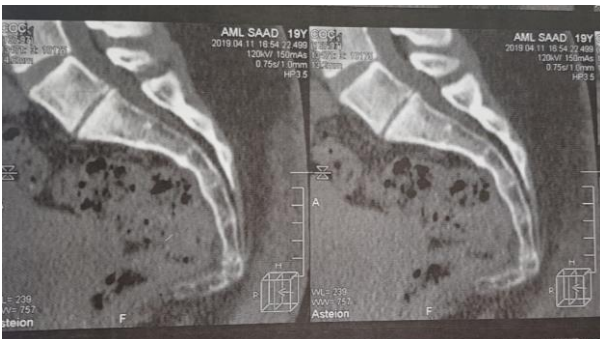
Preoperative Sagittal CT Sacrum and Coccyx in patient with showing anterior angulation of the coccyx.
